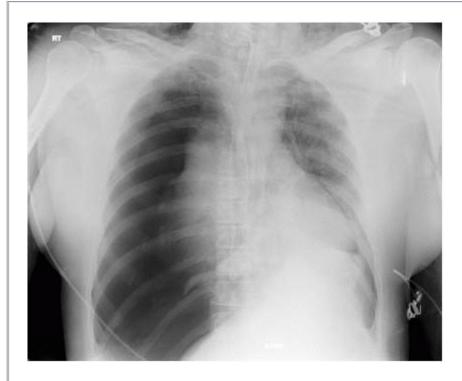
Radiograph showing a right-sided tension pneumothorax. There are no lung markings on the right of the chest. The mediastinum is shifted to the left and the right hemithorax is overinflated.
